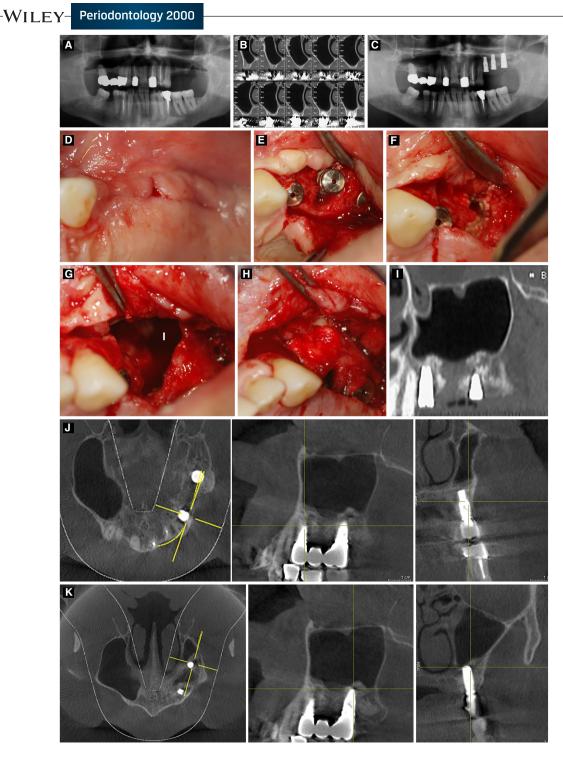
A, Preoperative panorex. B, Preoperative cone beam computed tomography depicting no significant anatomic findings; a healthy sinus. C, Immediate postoperative panorex. The surgery was carried out without any intraoperative complication. D, Week 2 postoperatively: Oroantral communication clinically noted, and patient was prescribed an additional round (7 days) of antibiotic therapy. E-H, Week 3 postoperatively: No clinical resolution observed, so partial graft and implant removal was completed via an intraoral approach with patient discussion and consent. Detailed clinical procedure follows. E, Original flap was elevated. Then, F, removal of the implant and, G, removal of loose graft particles was completed under copious saline irrigation. H, Subsequently, curettes were used to position viable graft and collagen sponge adjacent the antrostomy, followed by primary flap closure. I, Immediate postoperative cone beam computed tomography. J, The 11-year follow-up cone beam computed tomography at the level of the distal implant. K, The 11-year follow-up cone beam computed tomography at the level of the distal implant
